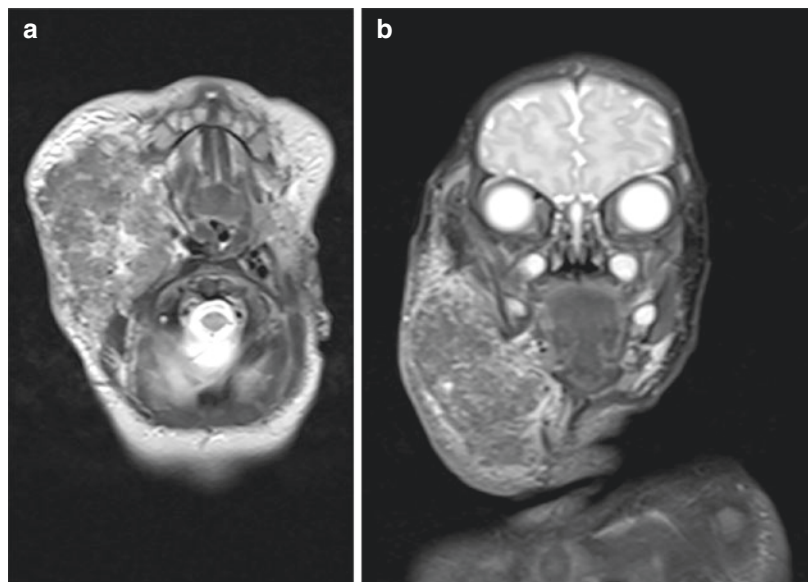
(a, b) MRI of a cervical KHE demonstrating the diffusely infiltrative nature of KHE, which makes clear margins difficult to obtain
